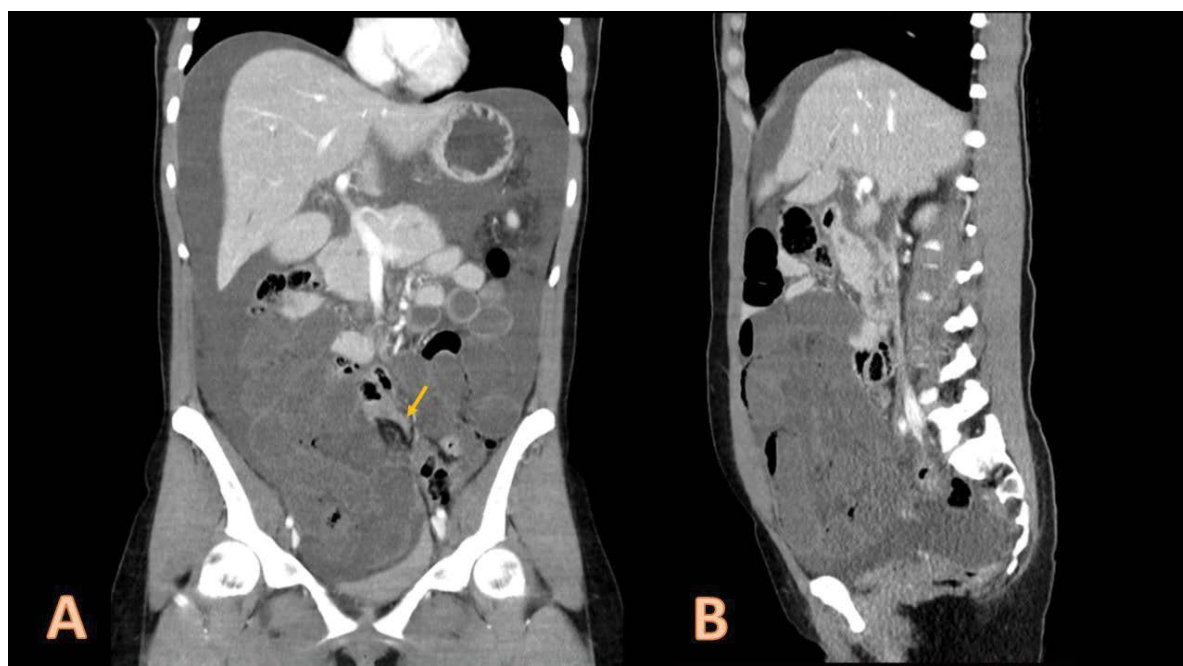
Abdominal CT scan with contrast medium administration (coronal and sagittal planes). Small bowel loops involvement (distal jejunum and proximal ileum) with submucosal edema and absence of enhancement after contrast. In addition, a change in caliber in the loop of the ileum located in the hypogastrium is identified (arrow). A significant increase in free intraperitoneal fluid with marked ascites was also observed. No signs of pneumoperitoneum or defined collections were detected.
